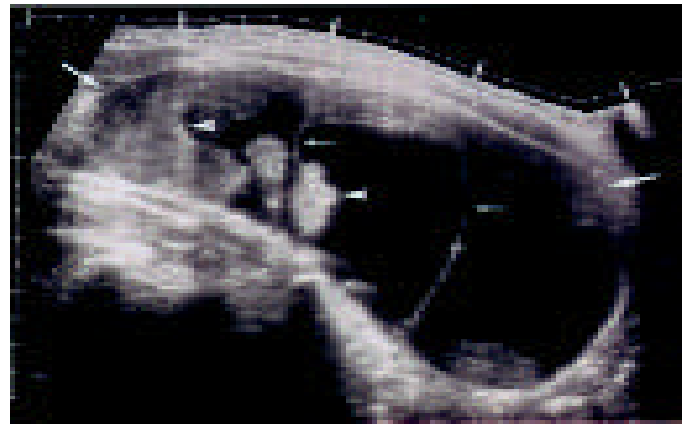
Ultrasonographic characteristics of a malignant adnexal mass.
